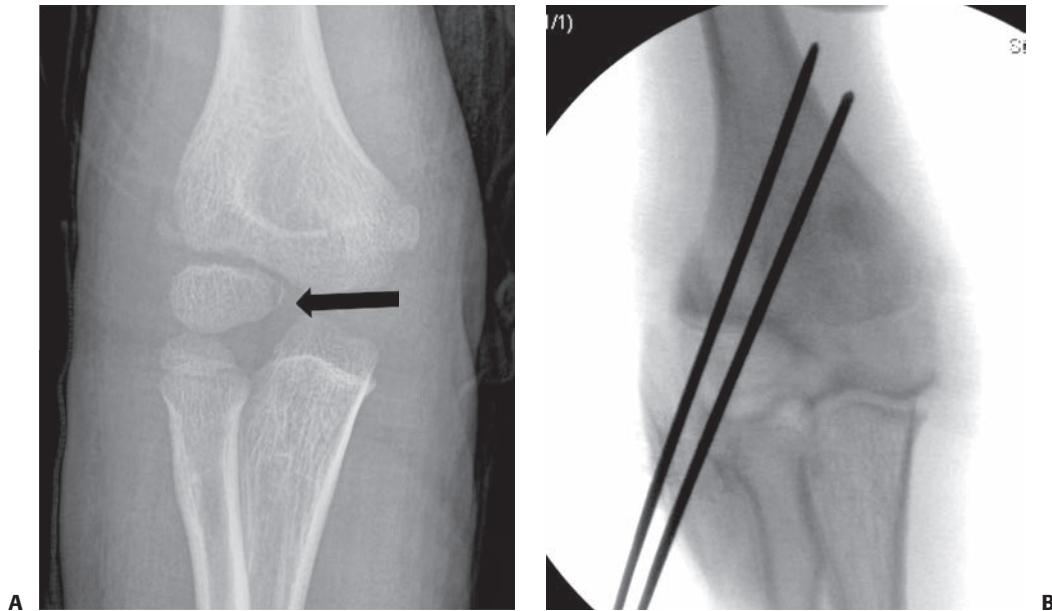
Stage II fracture of the lateral condyle. A: AP radiograph shows 4 mm of displacement with fracture line extending to nonossified trochlea (*arrow*). B: Intraoperative fluoroscopic image after pinning shows intact articular surface.
